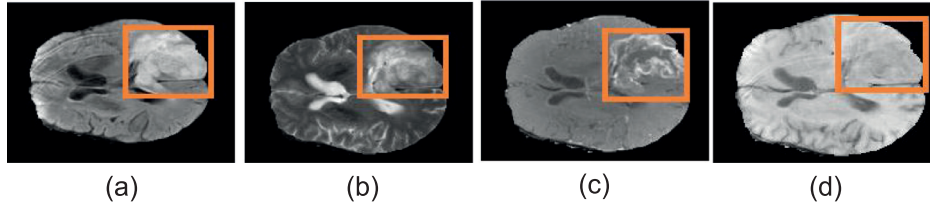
Four imaging sequences: (a) Flair MRI (b) T2 MRI (c) T1 MRI (d) T1c MRI.
